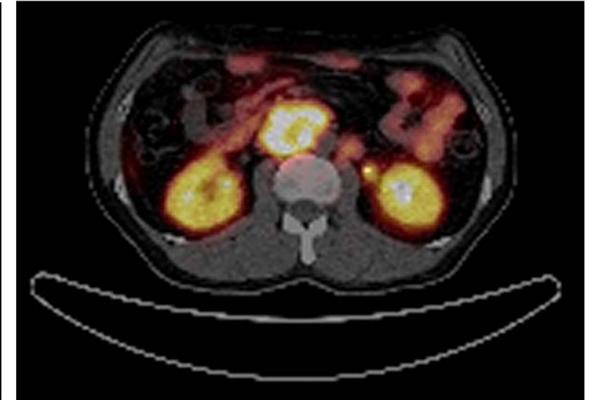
NM Ga68 Dotatate PET/CT neck
